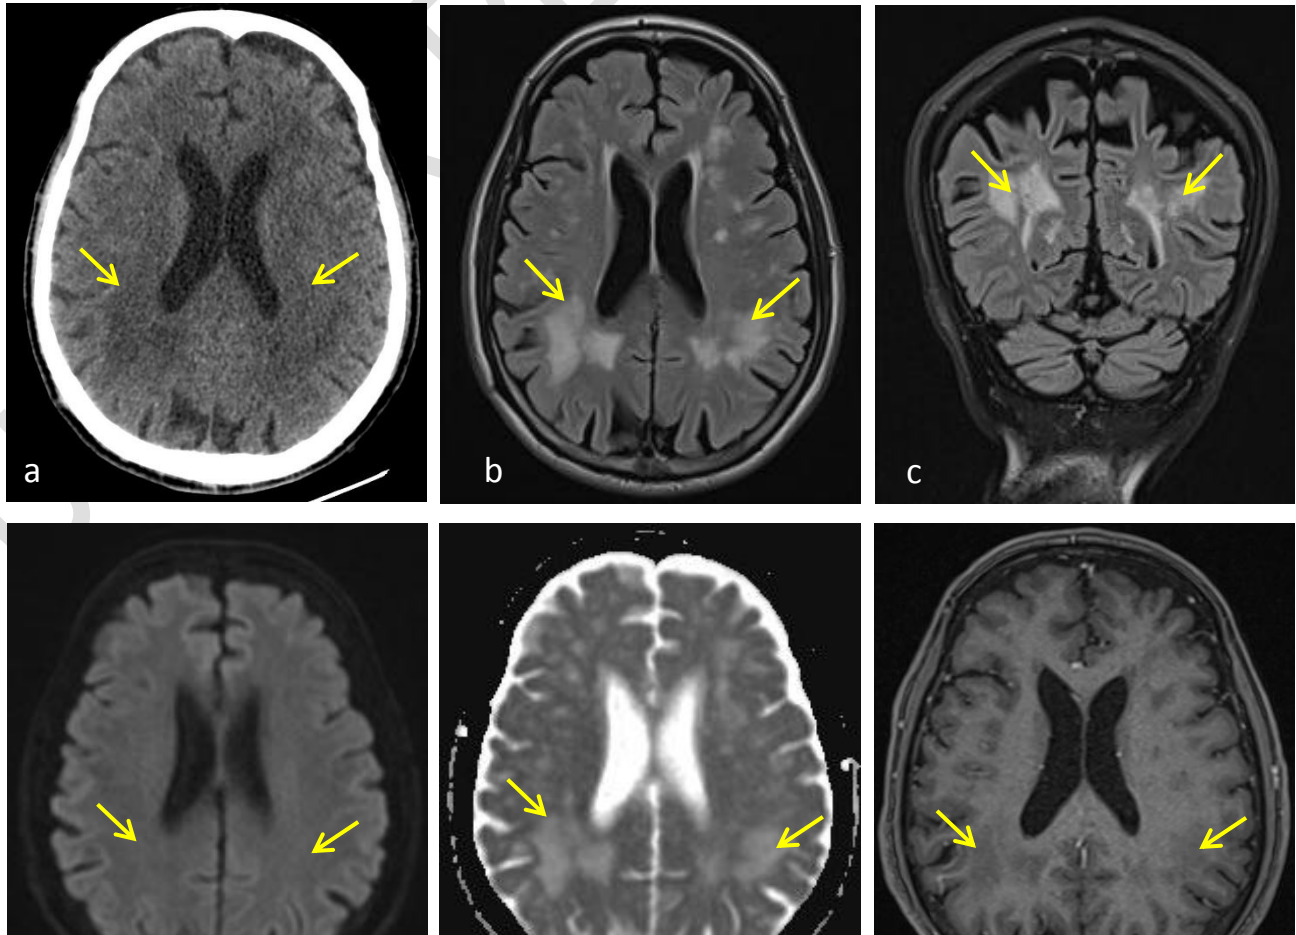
Brain CT (a) demonstrating frontal and parietal white matter hypodense areas (arrows), presenting as hyperintensities on axial and coronal T2-FLAIR (b & c), with no diffusion restriction on DWI and ADC map (d & e), and no enhancement after gadolinium administration (f).
